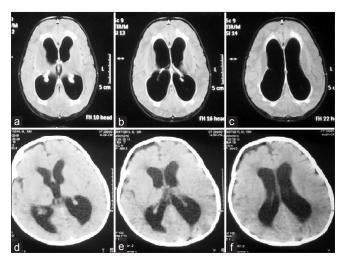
Preoperative magnetic resonance imaging scans (a-c) and postoperative computed tomography scans (d-f) showing decrease in the size of ventricles following endoscopic third ventriculostomy
